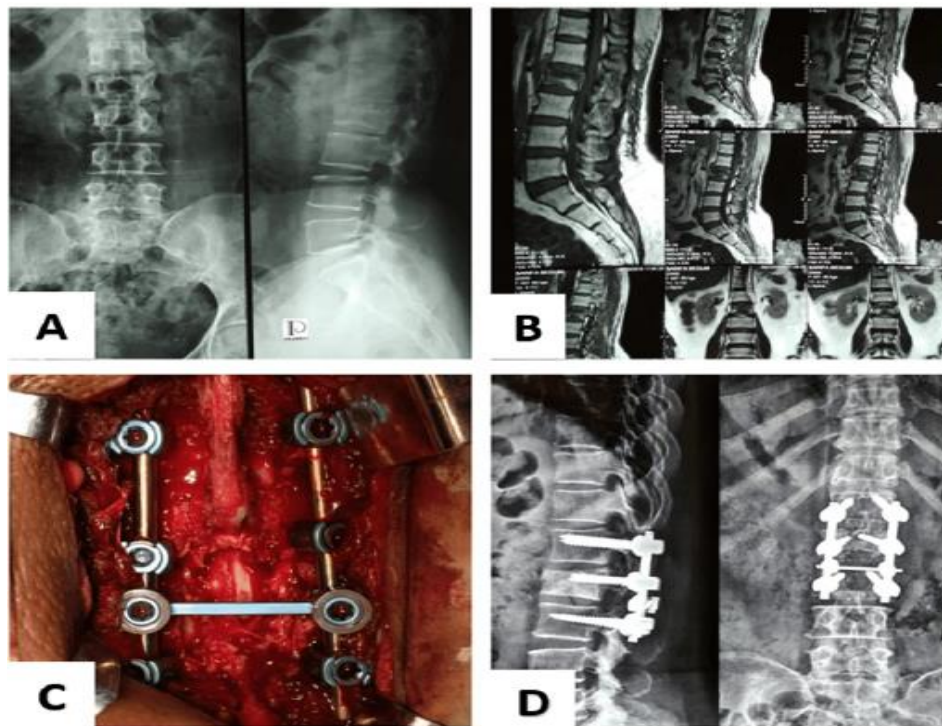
SHORT SEGMENT FIXATION OF L2 FRACTURE (A) PRE-OP X-RAYS (B) PRE-OP MRI (C) INTRA-OP PICTURE OF INSTRUMENTATION (D) POST-OP X-RAYS.(10)
